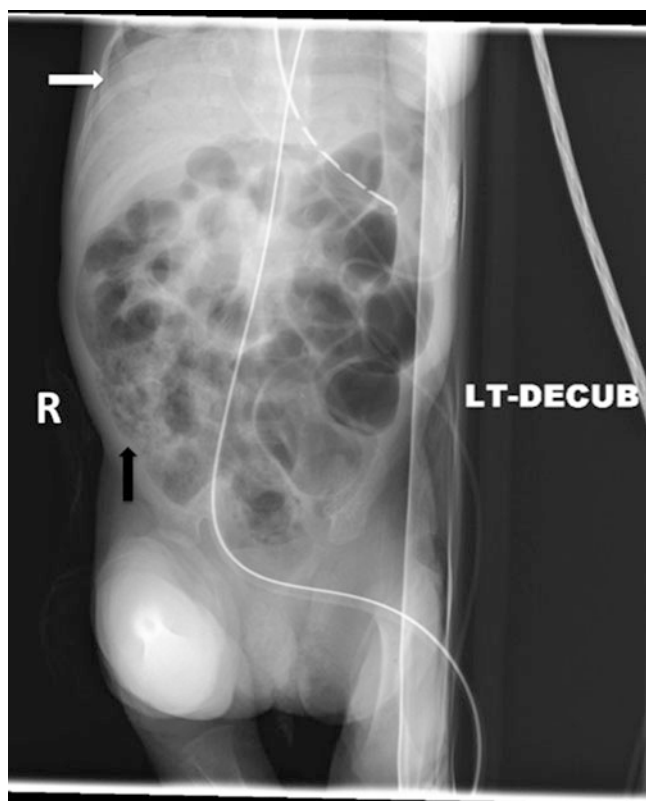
Left lateral decubitus radiograph demonstrating both portal venous gas (white arrow) and extensive pneumatosis intestinalis (black arrow) in an infant with NEC
